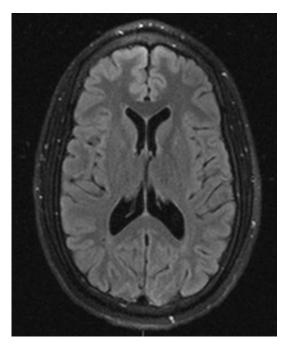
Axial view T2 FLAIR MRI imaging 2 years after initial presentation showed complete resolution of brain lesions.
